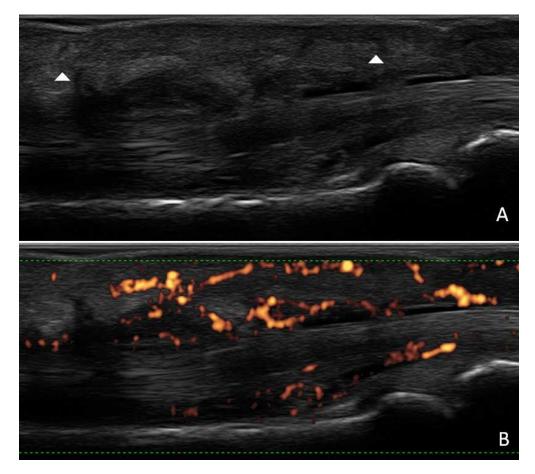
Longitudinal views of dactylitis belonging to the first group (dactylitis duration shorter than 20 weeks). (A) Ultrasound shows flexor tenosynovitis of grade 2 with soft tissue oedema (white arrowheads) whereas joint synovitis is absent. (B) Power Doppler signal (PDS) is present around the tendon fibers and in subdermal tissue; intra-articular PDS is absent.
